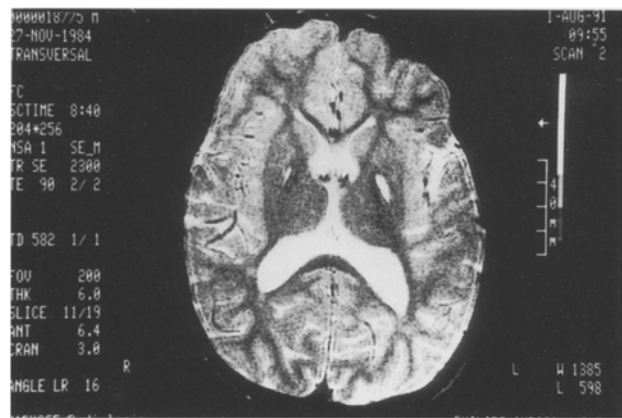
MR image (1.5 Tesla superconductive magnet system) of a 4.5-year-old boy with MMA: left demonstrating symmetrical areas of low signal intensity within the central portions of the basal ganglia (globus pallidus) on T1-weighted partial saturation spin echo and inversion recovery pulse sequences; right demonstrating high signal intensity areas, isointense to cerebrospinal fluid on proton density and T2-weighted images
